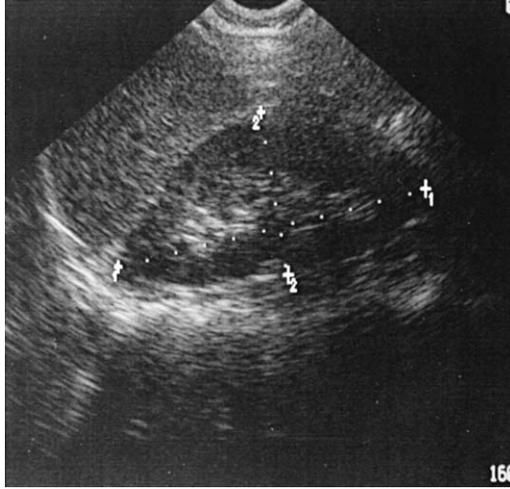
Longitudinal view of normal kidney with length and width measurements. (From Brown DFM, et al. Renal ultrasonography. *Emerg Med Clin N Am* 1997;15:887; with permission.)
